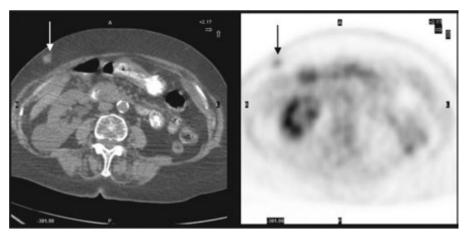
CT (A) and PET (B) scan of the abdomen showing a solitary mass in the right anterior abdominal wall (arrows) in a patient with a lung tumour. The mass is PET positive.
